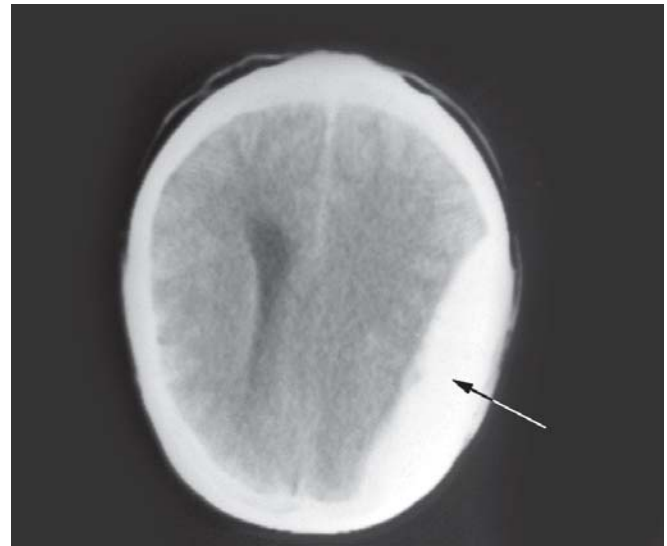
CT head showing large extradural hematoma (biconvex) with ventricular effacement and midline shift
